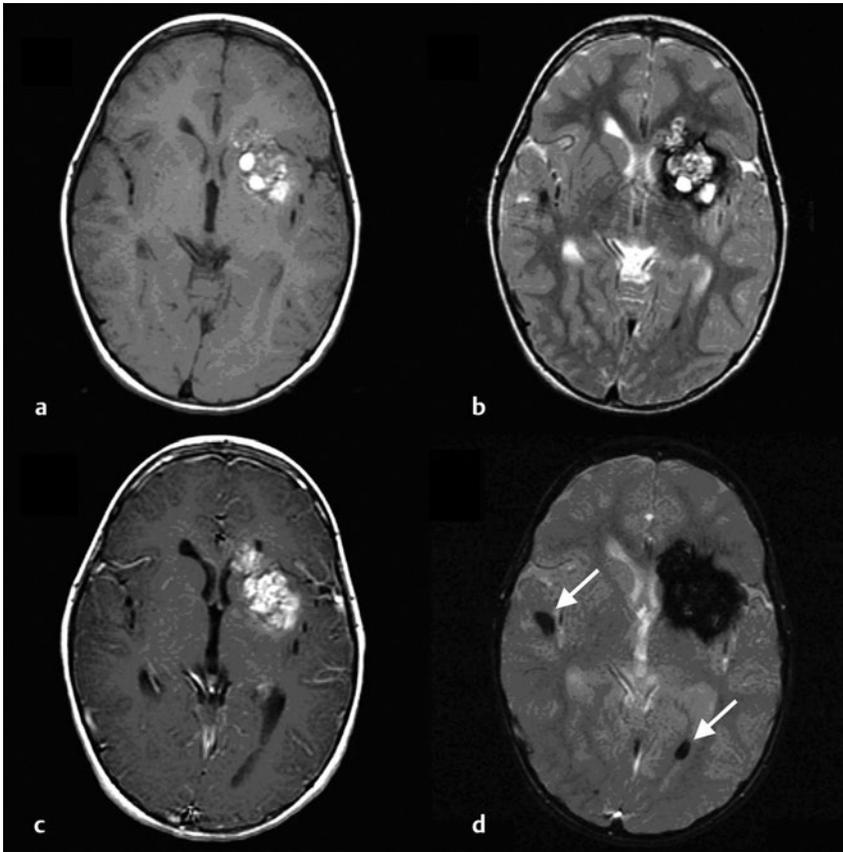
Magnetic resonance imaging sequence. (a) T1, (b) T2, (c) T1 with contrast, and (d) gradient-echo images of the same patient as in ► Fig. 64.6 show a large type 2 lesion, with two small type 4 lesions (arrows) evident on the gradient-echo image.
